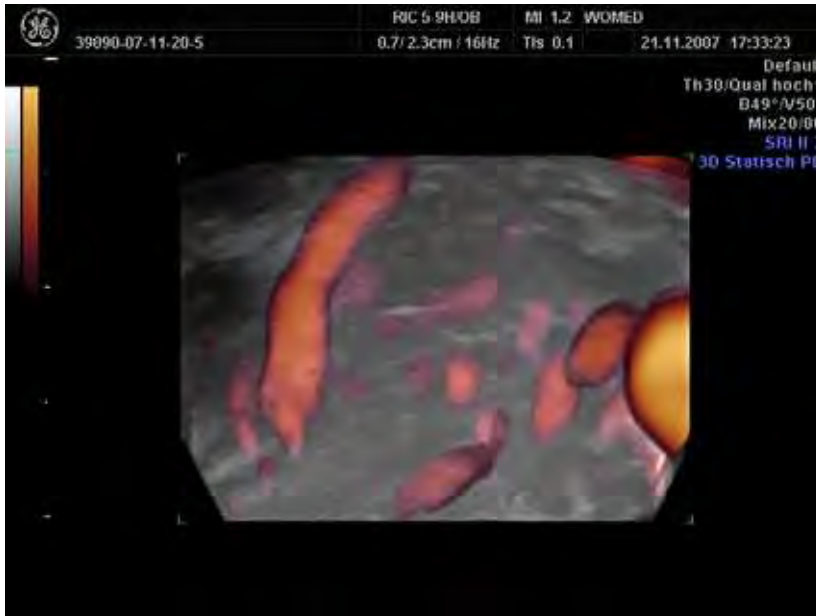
Case 1. Normal thyroid seen in 3-D power Doppler modus using a vaginal transducer. The thick vessel corresponds to a laryngeal artery
